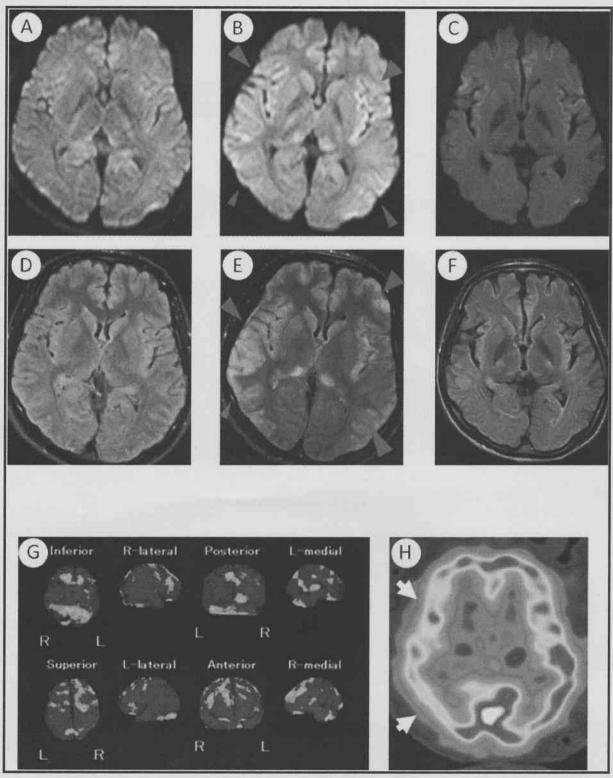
Axial diffusion-weighted (DW) images at 9 (A), 72 (B), and 271 (C) days of onset. Axial fluid attenuated inversion recovery (FLAIR) MR images at 9 (D), 72 (E), and 271 (F) days of onset. Note that there are no remarkable findings in (A) and (D), but high signal intensity is present in the cortex of bilateral anterior, temporal, and parietal lobes in DW (B) and FLAIR (E) images at 72 days (arrowheads). MRI abnormalities disappeared at 271 days of onset (C, F) 116 days after initiating ketogenic therapy. (G) ^{99m}Tc-ECD SPECT showing a decrease in right anterior cerebrocortical and left cerebellocortical blood flow in eZIS analysis at 10 days of onset. (H) SPECT with ¹²³I-iomazenil showing a decrease in ¹²³I-iomazenil uptake in the right temporal and parietal lobes at 12 days of onset (arrows).
